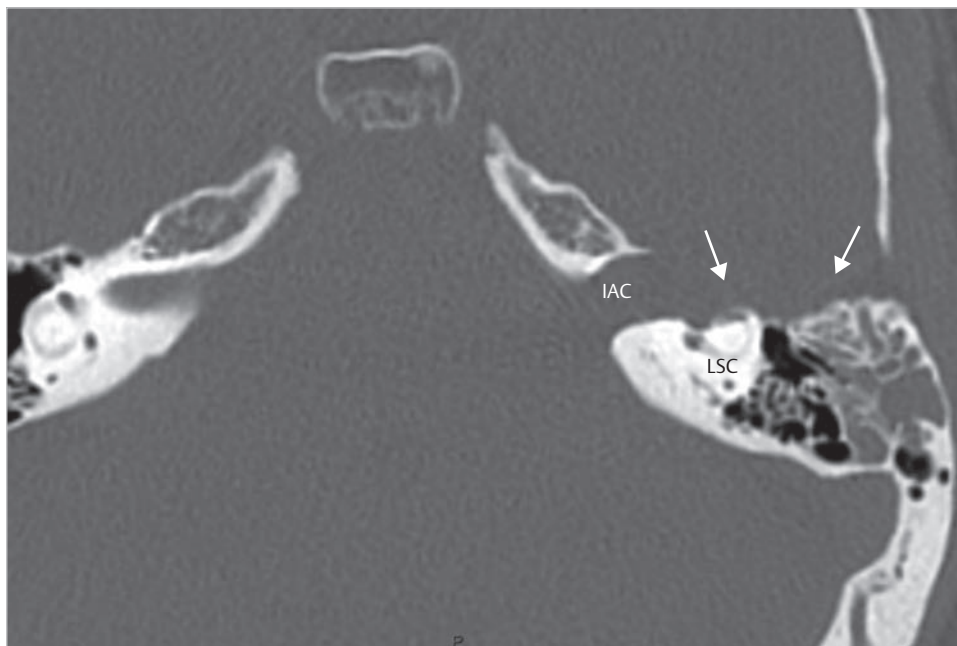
Preoperative CT shows bone erosion in the anterior part of the pyramidal bone (*arrows*). Erosion of the lateral semicircular canal and enlargement of the internal auditory canal are identified. IAC, internal auditory canal; LSC, lateral semicircular canal.
